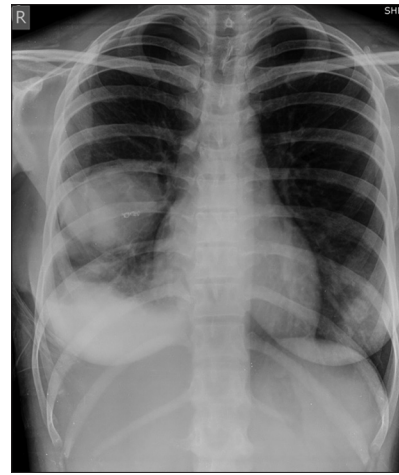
Chest X-ray showing cannon ball opacities in bilateral lower zones
